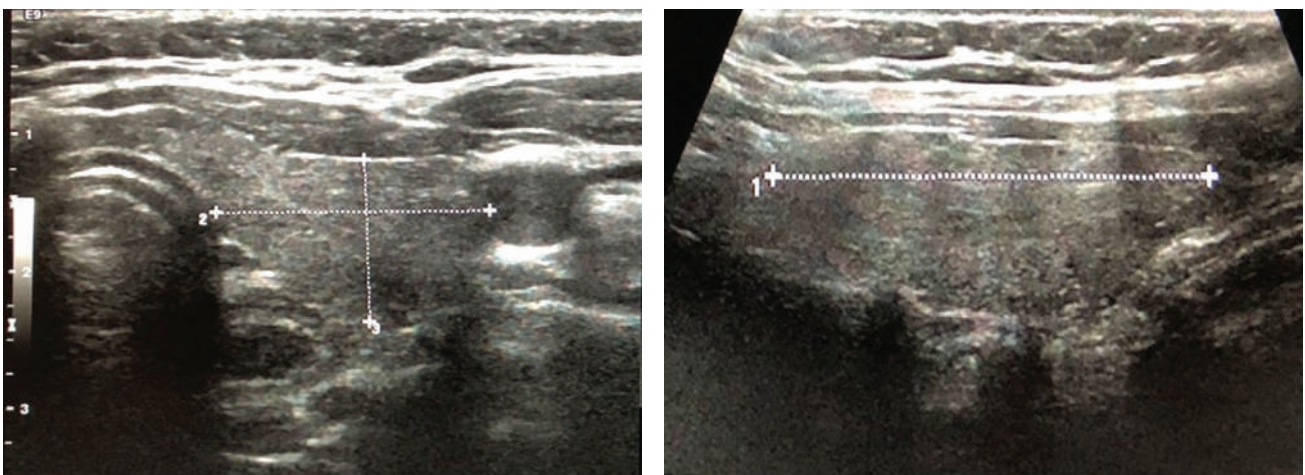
Ultrasound of the left thyroid lobe: The left lobe measured 4.2 x 2.4 x 2.1 cm, with x 10 magnification.
